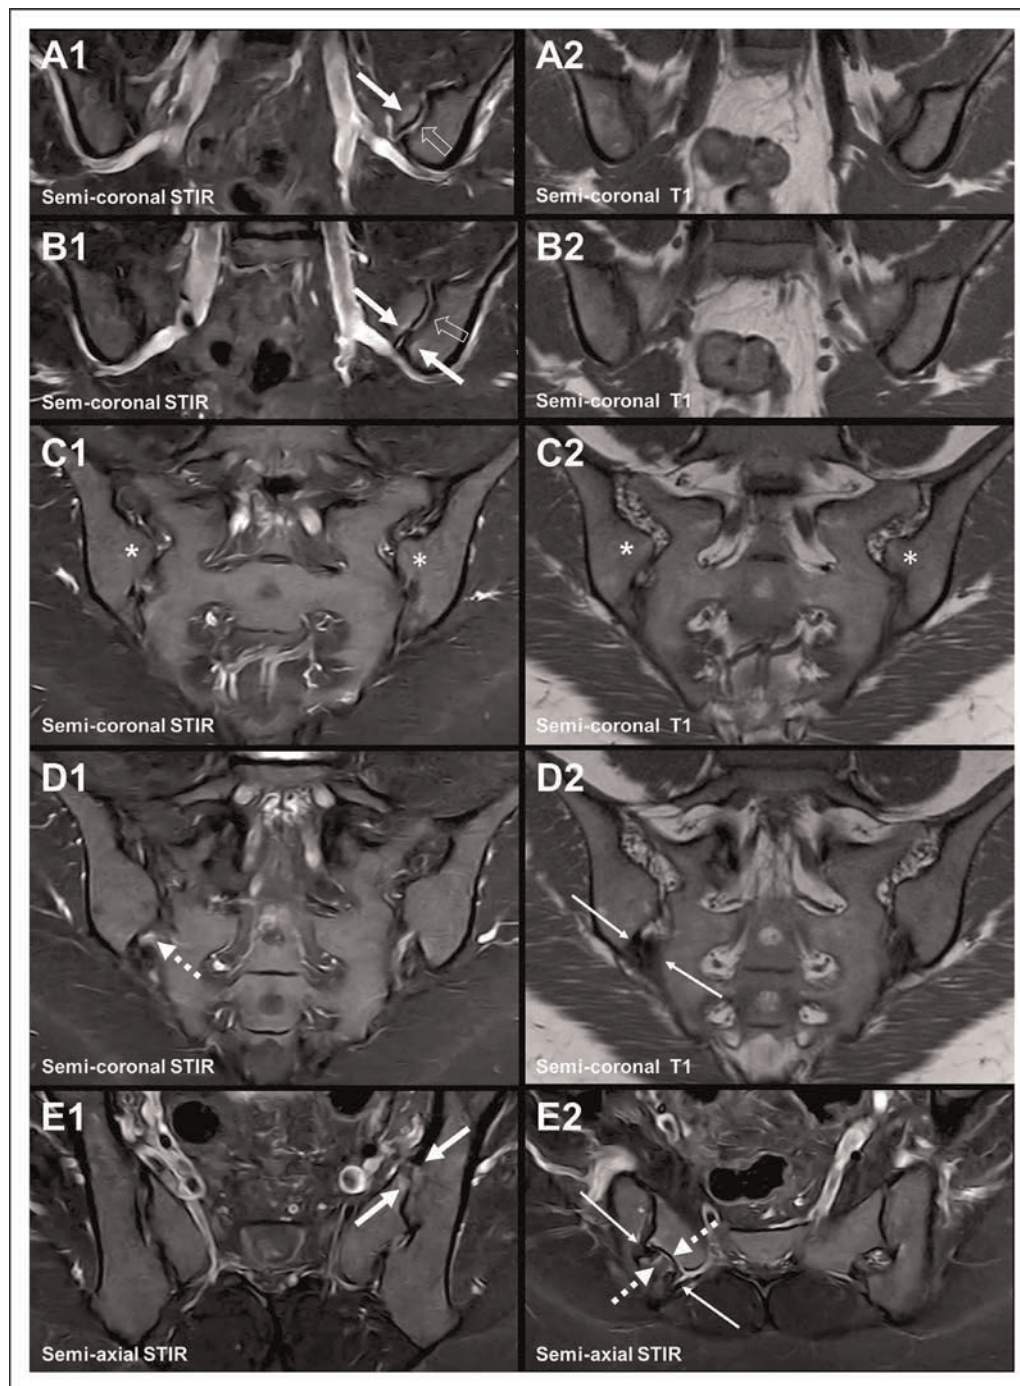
Accessory sacroiliac joint and iliosacral complex with concomitant bone marrow edema. MRI in a 27-year-old woman with pelvic pain due to a gynecological tumor. No clinical or biochemical findings suggesting sacroiliitis. Semi-coronal STIR (a1, b1, c1, d1) and corresponding T1-weighted images (a2, b2, c2, d2), two consecutive images anteriorly (a1/a2, b1/b2) and two consecutive images posteriorly (c1/c2, d1/d2) in the joint with supplementary semi-axial STIR images at the middle (e1) and lower part (e2) of the joints. There is bilateral iliosacral complex between the first and second sacral segment (asterisk on c1, c2) and a right-sided accessory joint (long slim arrows on d2, e2). There is concomitant subchondral BME anteriorly at the left SIJ (white arrows on a1, b1, e1) and joint fluid (open arrows on a1, b1). The accessory joint is seen on both the semi-coronal and semi-axial images (long slim arrows on d2, e2), but the exact location of adjacent BME (dashed arrows on d1, e2) is only visualized on the semi-axial image (e2). BME, bone marrow edema; SIJ, sacroiliac joint; STIR, Short Tau Inversion Recovery.
